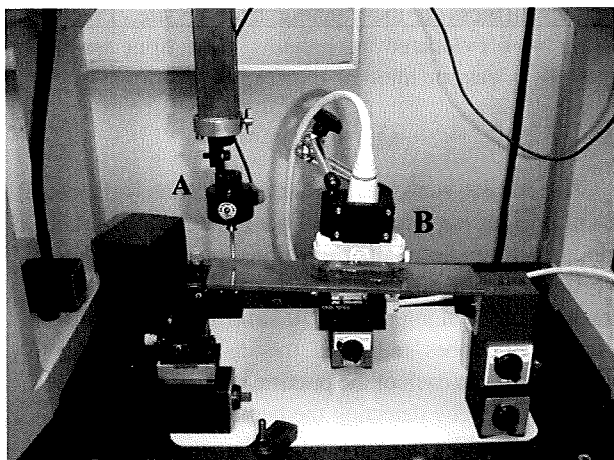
The accuracy of the ET measurement was evaluated by measuring the inclination of the flat metal panel simultaneously using a 3-D measuring device. (A) 3-D measuring device; (B) 7.5-M Hz linear ultrasound probe.
